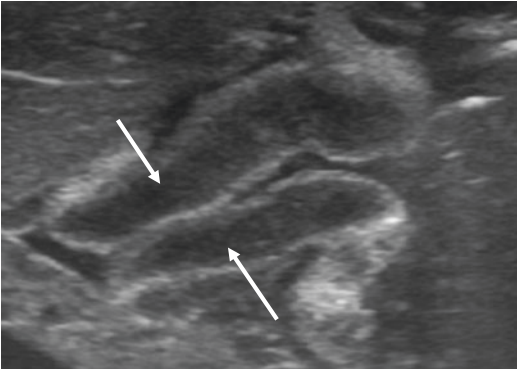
Prostaglandin-induced antral mucosal hypertrophy in a 23-day-old boy post cure of a left diaphragmatic hernia. Ultrasound with high frequency probe shows marked antral mucosal thickening (*arrows*) without thickening of the pyloric muscle
